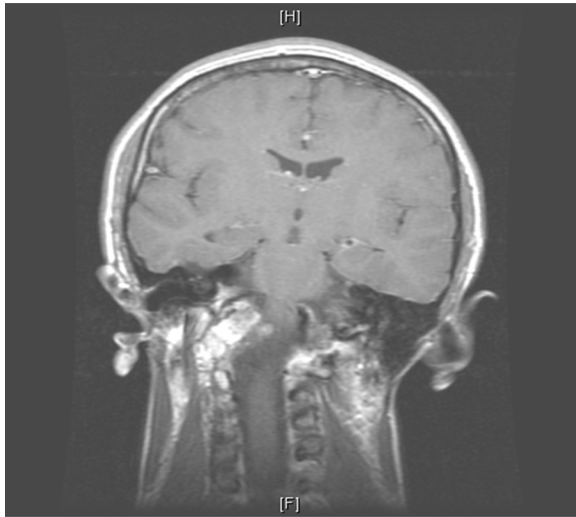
Same patient as Fig. 1. MRI aspect at 84 months follow-up, showing radiotherapy-related bony alterations at C1-C2 (personal coll.).
